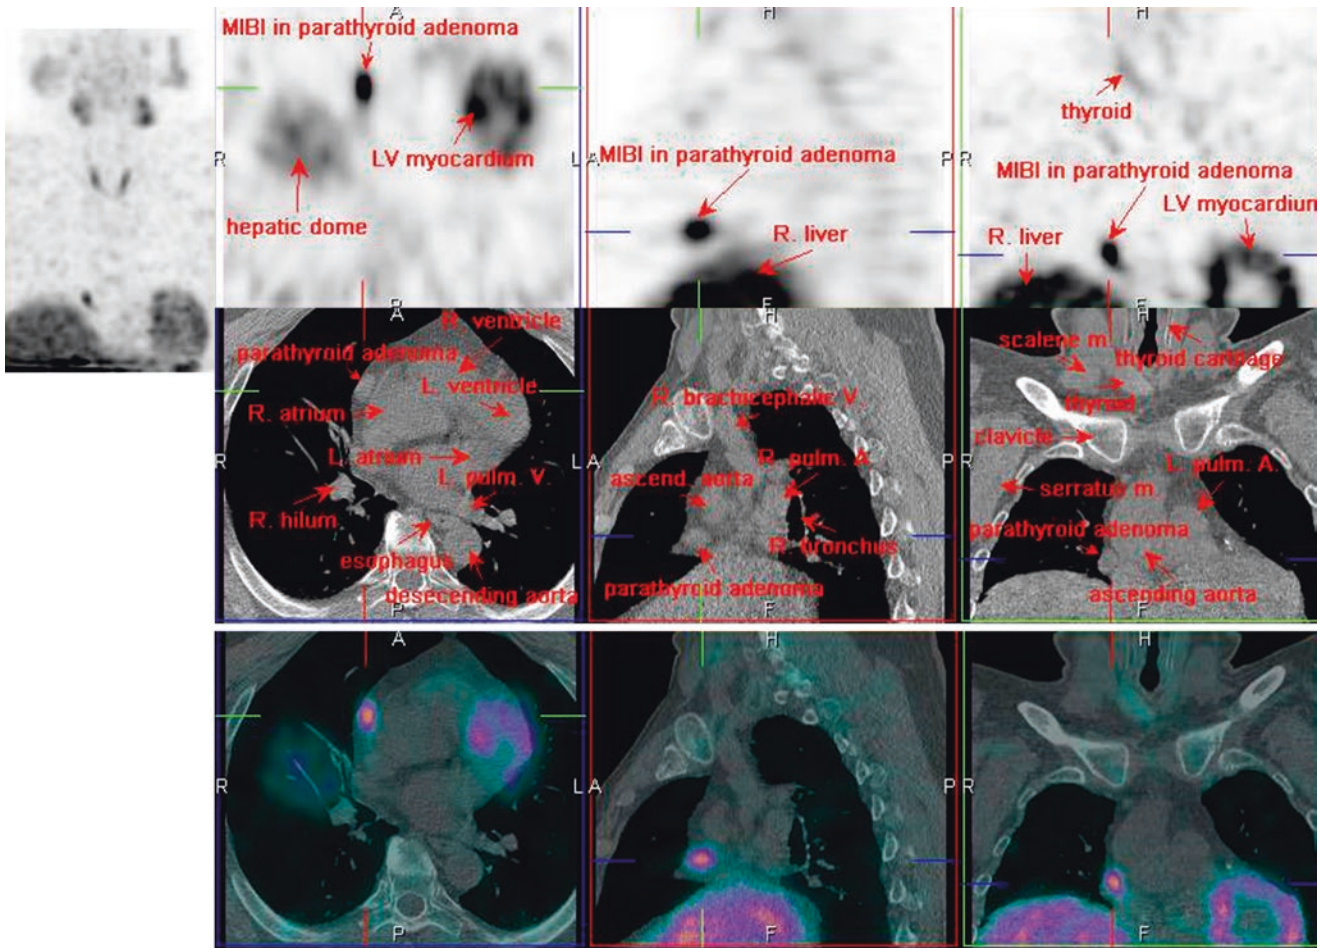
^{99m}Tc-MIBI SPECT/CT
